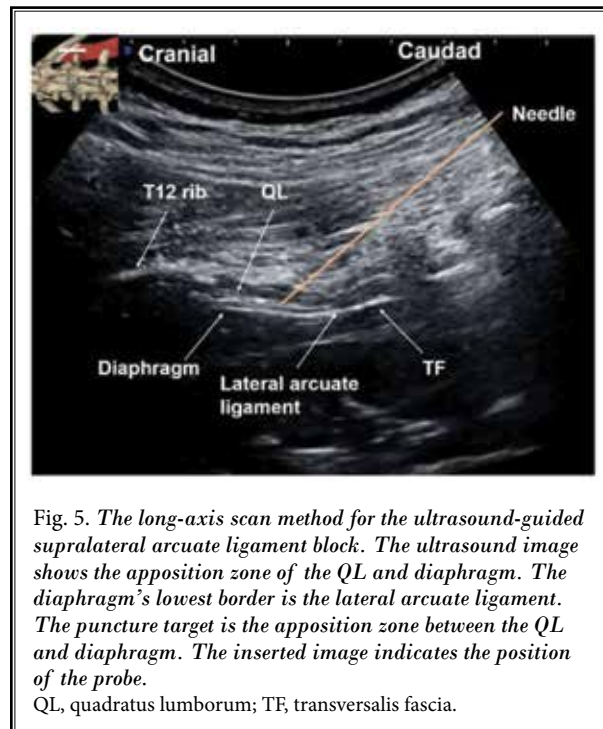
The long-axis scan method for the ultrasound-guided supralateral arcuate ligament block. The ultrasound image shows the apposition zone of the QL and diaphragm. The diaphragm's lowest border is the lateral arcuate ligament. The puncture target is the apposition zone between the QL and diaphragm. The inserted image indicates the position of the probe.
